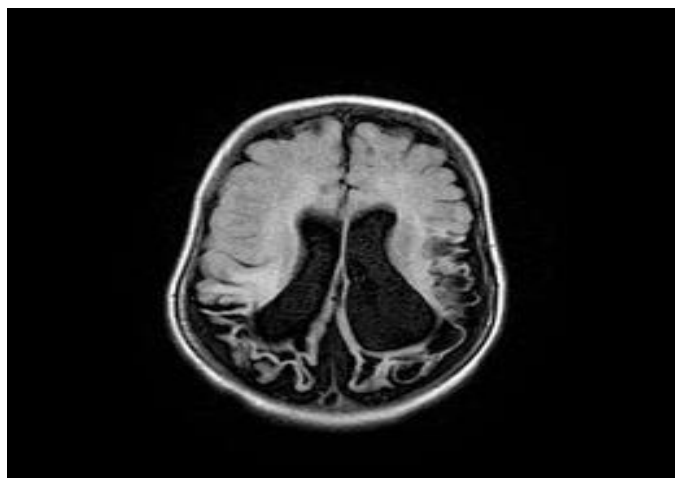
FLAIR axial Sequence in MRI showing
